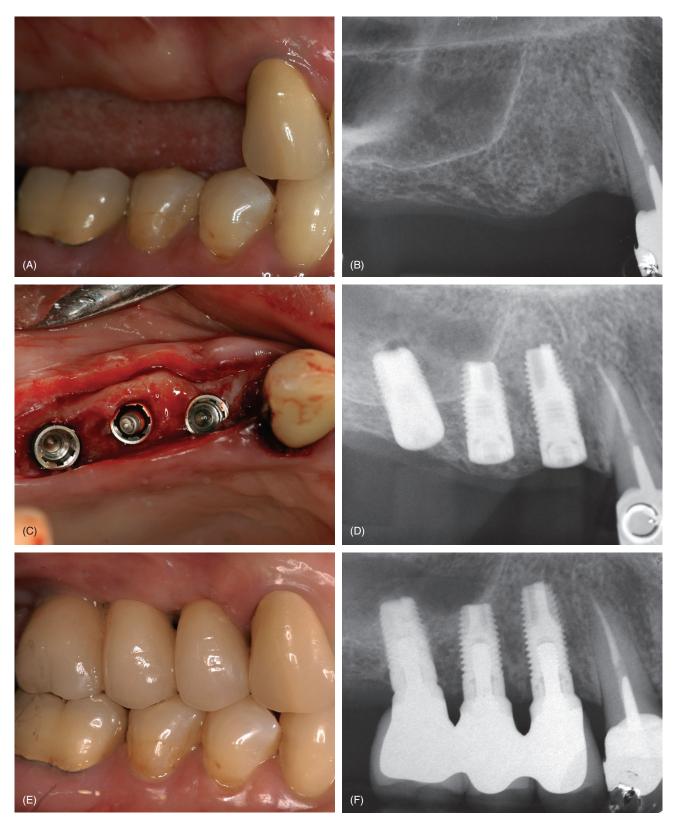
(A) Clinical photo prior to treatment. (B) Preoperative radiograph. (C) Showing three implants where the most distal was placed using the osteotome technique. (D) Postoperative radiograph. (E) Showing final prostheses. (F) Follow-up radiograph after 1 year. Note bone formation at the apex of the distal implant.
